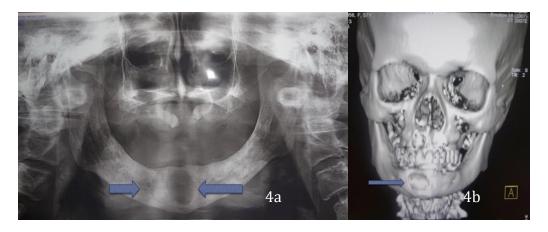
Panoramic radiograph (a) and NECT scan (b) showing two cystic structures in the mandible.
